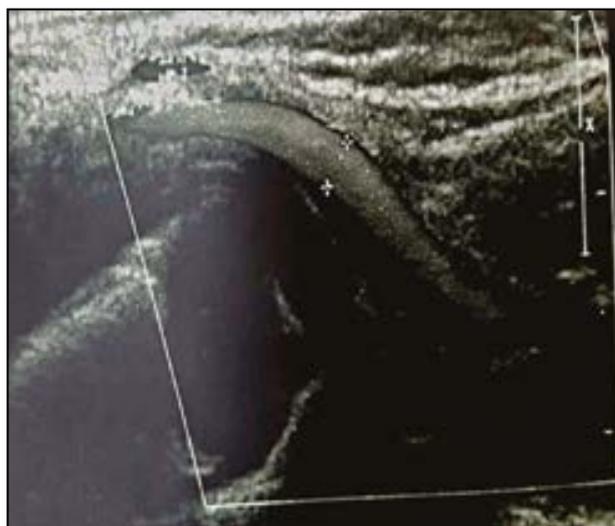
Ultrasonographic examination. The brachial artery is patent
